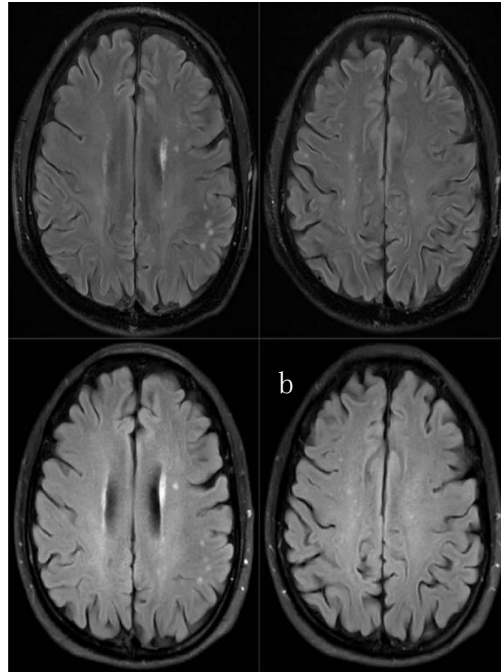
5T images reveal a greater number of lesions and display clearer lesion boundaries compared to the 3T images. 3a, 3c: T2-FLAIR images of the same participant. 3b, 3d: T2-FLAIR images of the same participant. 3a, 3b were acquired using a 5T scanner, and 3c, 3d were acquired using a 3T scanner.
